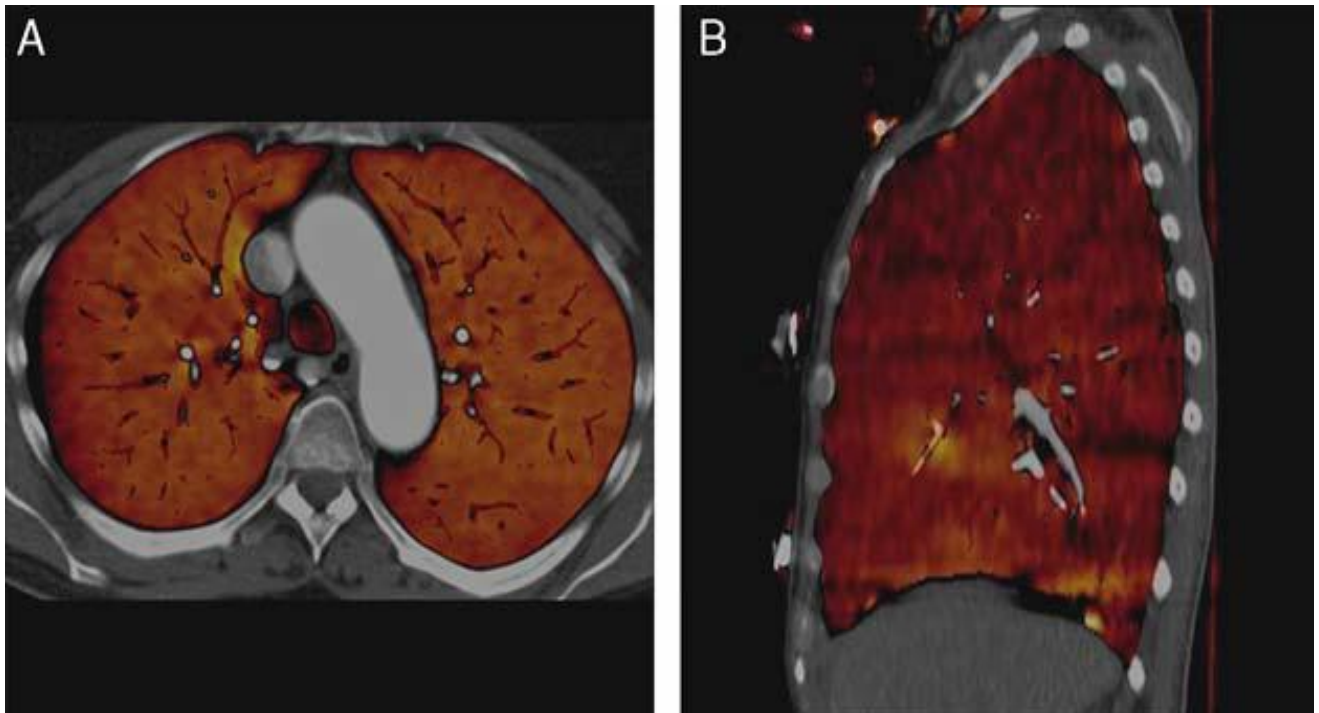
Axial (A) and sagittal (B) dual energy CT. Iodine map shows homogenous perfusion signal intensity in keeping with no pulmonary embolism (attenuation range of -960 HU and -600 HU)[17]
